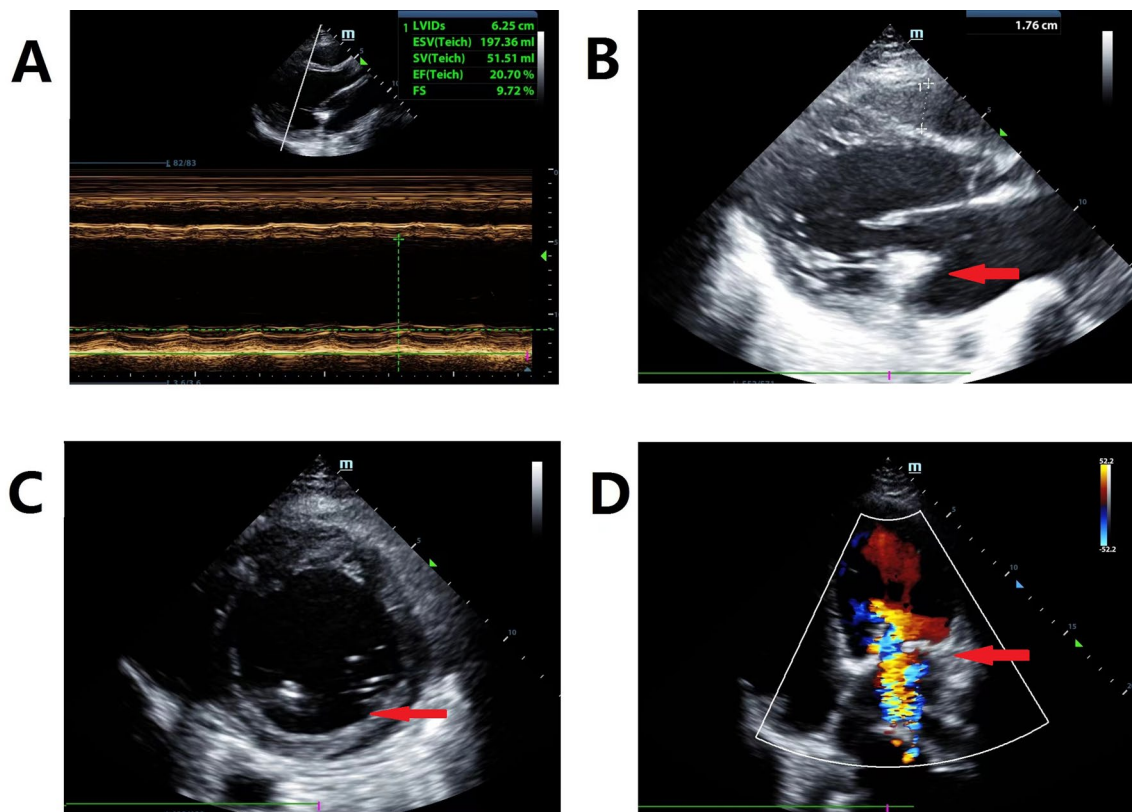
The echocardiography was performed on day 2 after admission. A The left ventricular ejection fraction decreased to 25%, with left ventricular and atrial enlargement. B The density of mitral was increased (red arrow), indicating previous mitral valve repair or replacement surgery. C Enlarged left ventricle with an increase in the number of endocardial papillary muscles (red arrow). D Mitral stenosis with incomplete closure (red arrow) was present
